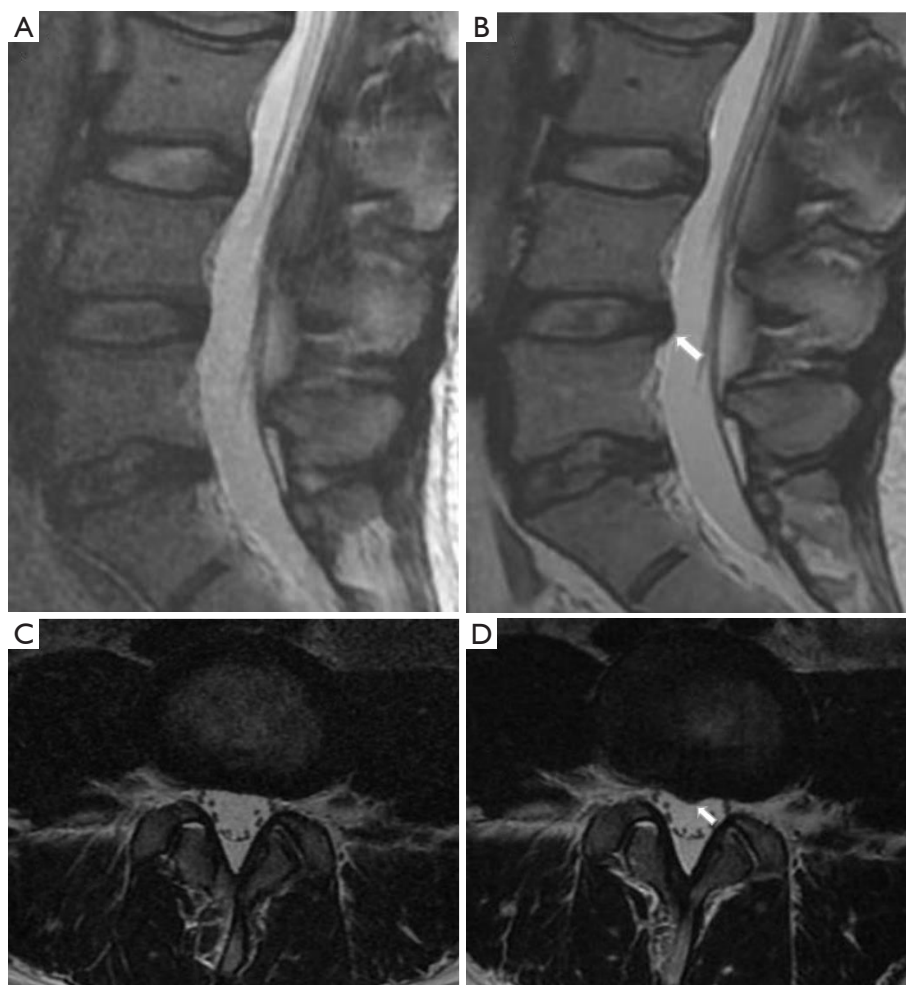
An asymptomatic 35-year-old man. Sagittal T2-weighted FRFSE of conventional MRI (A) and axial loading MRI (B), with disc herniation at L4-5 (arrow). Axial T2-weighted FRFSE of conventional MRI (C) and axial loading MRI (D), also with disc herniation (arrow), and a reduced DSCA from 128.13 to 109.23 mm² after axial loading. FRFSE, fast recovery fast spin-echo; MRI, magnetic resonance imaging; DSCA, dural sac cross-sectional area.
